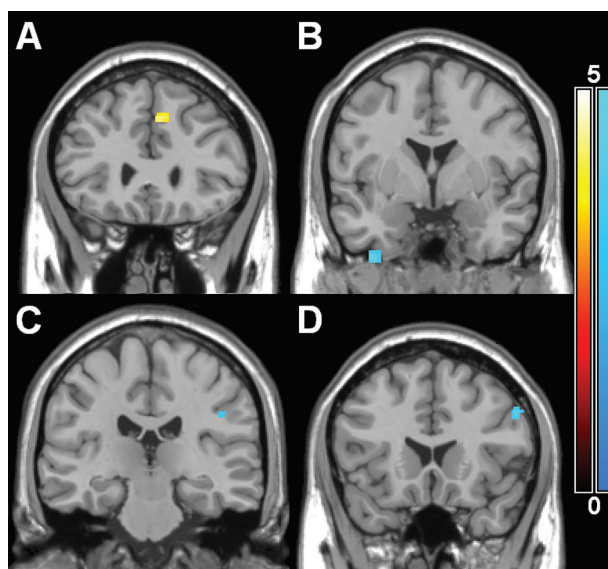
Statistical parametric maps demonstrating increases (yellow) and decreases (blue) in DSC-MRI measured cerebral blood flow (CBF). Increases in CBF between migraineurs and controls in the medial frontal gyrus (A) and decreases in CBF between MA patients and controls in the inferior temporal gyrus (B) and postcentral gyrus (C) and between MO patients and controls in the inferior frontal gyrus (D) are superimposed on a T_1 -weighted template in MNI standard space. Color bars represent Z-values. The left side of each picture is the right side of the brain.
